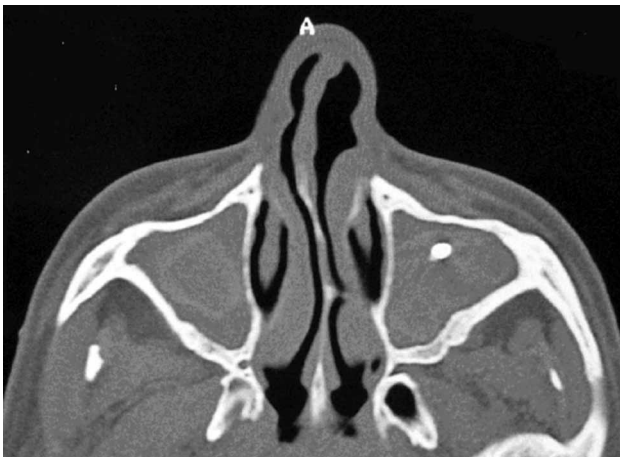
Computed tomographic scan. Axial view showing a bilateral maxillary sinus fungus ball (*Aspergillus fumigatus*) without involvement of other sinus cavities.
